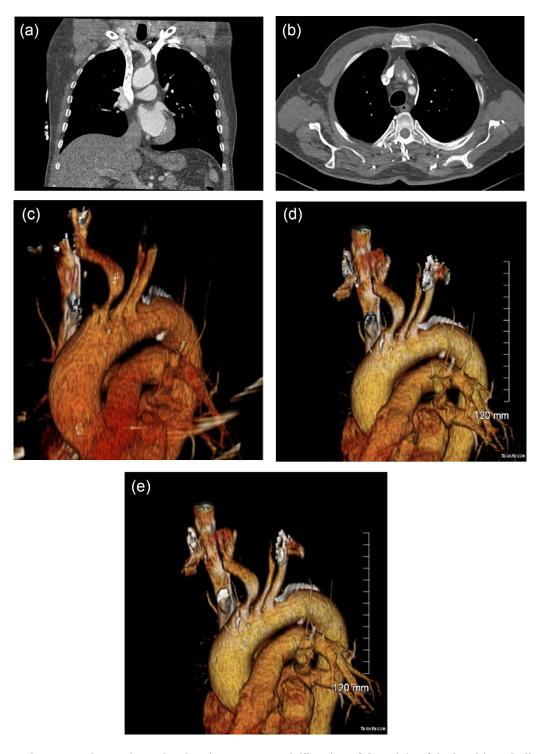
Computed Tomography Angiography showing aneurysmal dilatation of the origin of the brachiocephalic trunk (measuring 3.5 cm) with a large volume ulcerated soft plaque. Complete occlusion of the right internal carotid artery through its course, with distal reconstitution, distal reconstitution in its supraclinoid segment, likely from collaterals.
